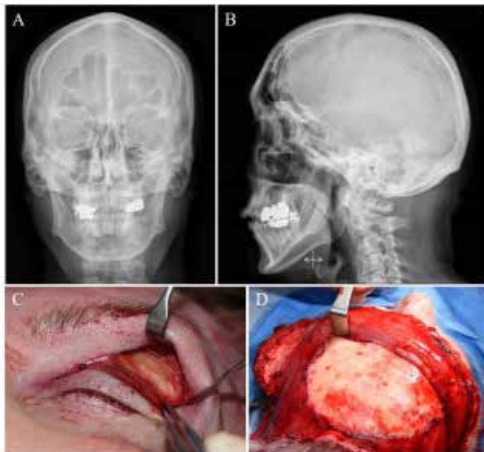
Skull x-ray demonstrating frontal (A) and sagittal (B) views of the bony structure of the forehead and frontal sinus. Note that this patient did not have a frontal sinus prominent enough to require a frontal sinus osteotomy.
